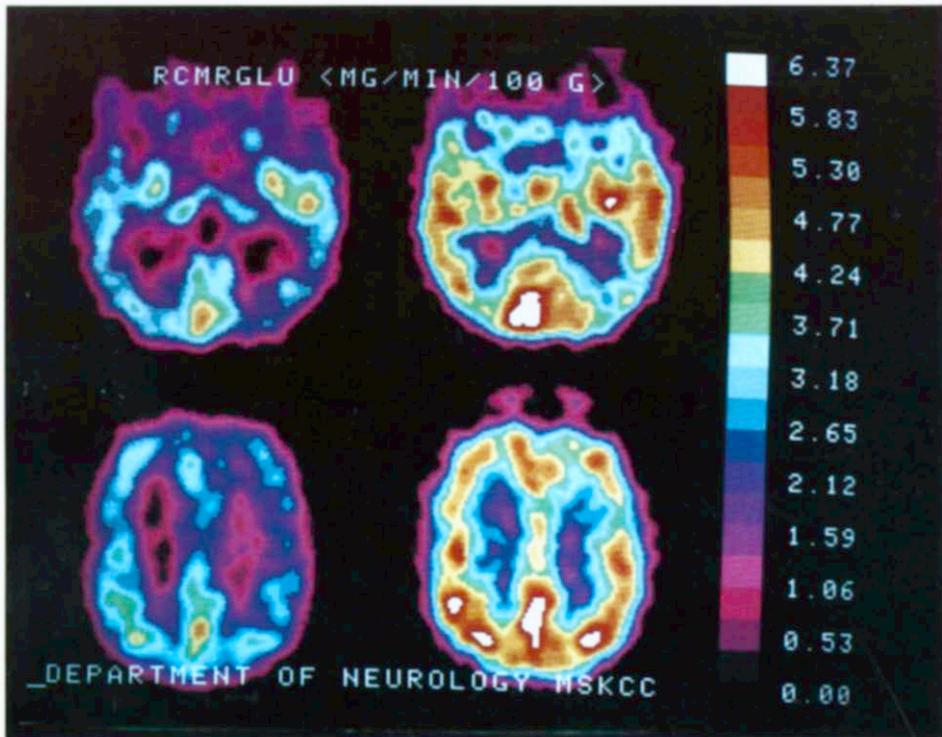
FDG/PET images of regional cerebral metabolic rate for glucose (rCMRGLu) in the unstimulated (left tier) and stimulated (right tier) states. Images in the upper and lower rows correspond to PET brain slices at the level of the thalami and the semioval centers, respectively. The global increase in cerebral metabolic rate for glucose associated with right thalamic stimulation becomes apparent when the left tier images are compared with the co-planar images to the right. The right side of the scan is the patient's right.
